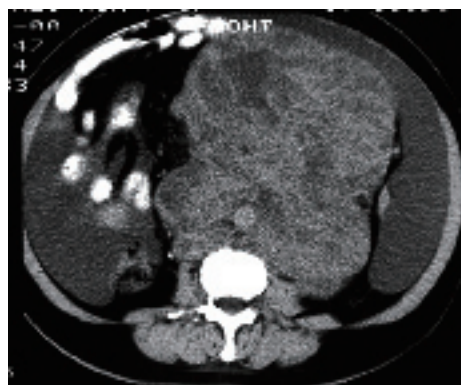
Solitary mass type: Enhanced CT showing multiple enlarged lymph nodes fused into uneven density, huge lobular tumors with abdominal aorta and inferior vena cava encased and ascites.
